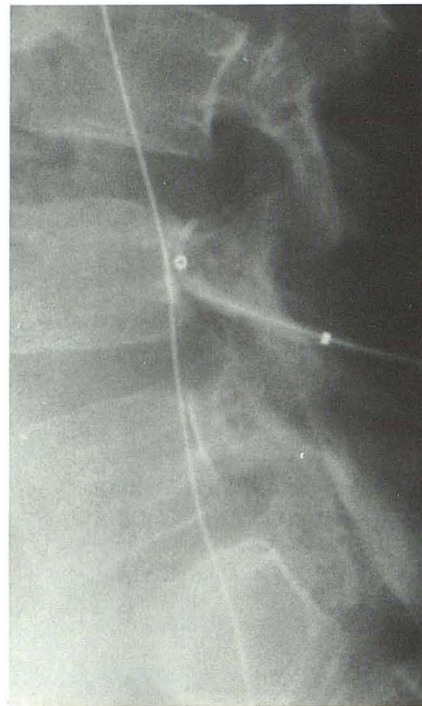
Lateral radiograph shows penetration of ventral cord with distended balloon catheter.
